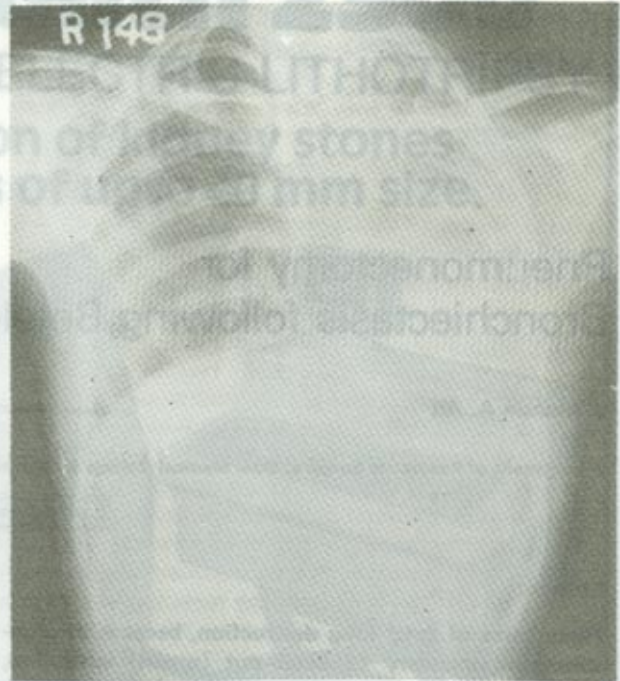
Case 1, plain X-ray showing abscess cavities in left lung.
